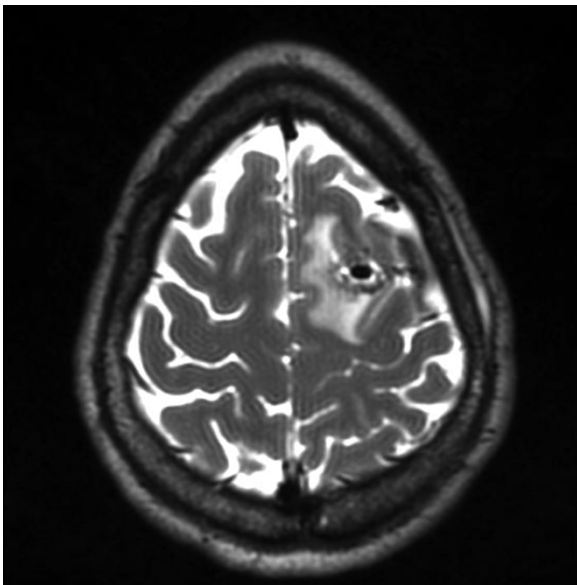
T2 MRI brain of patient 1.
